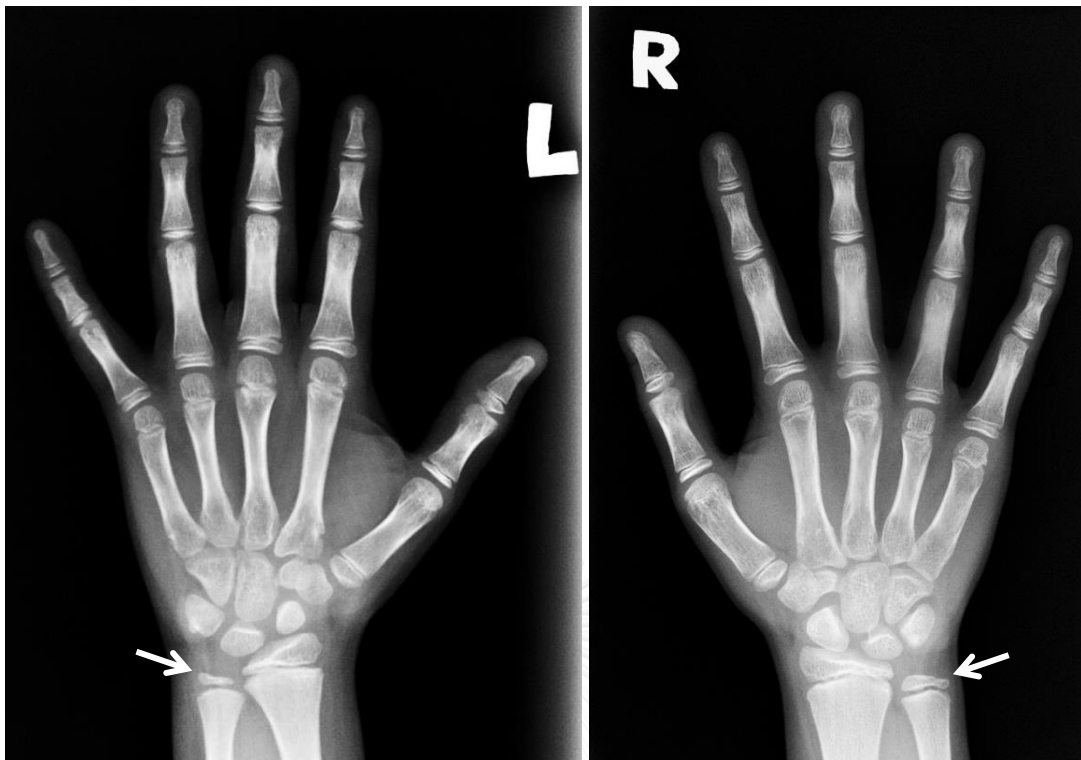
A hand and wrist radiograph showing ulna epiphysis with prominent styloid process (left) and a hand and wrist radiograph showing wider ulna epiphysis with poorly defined styloid process (right).
